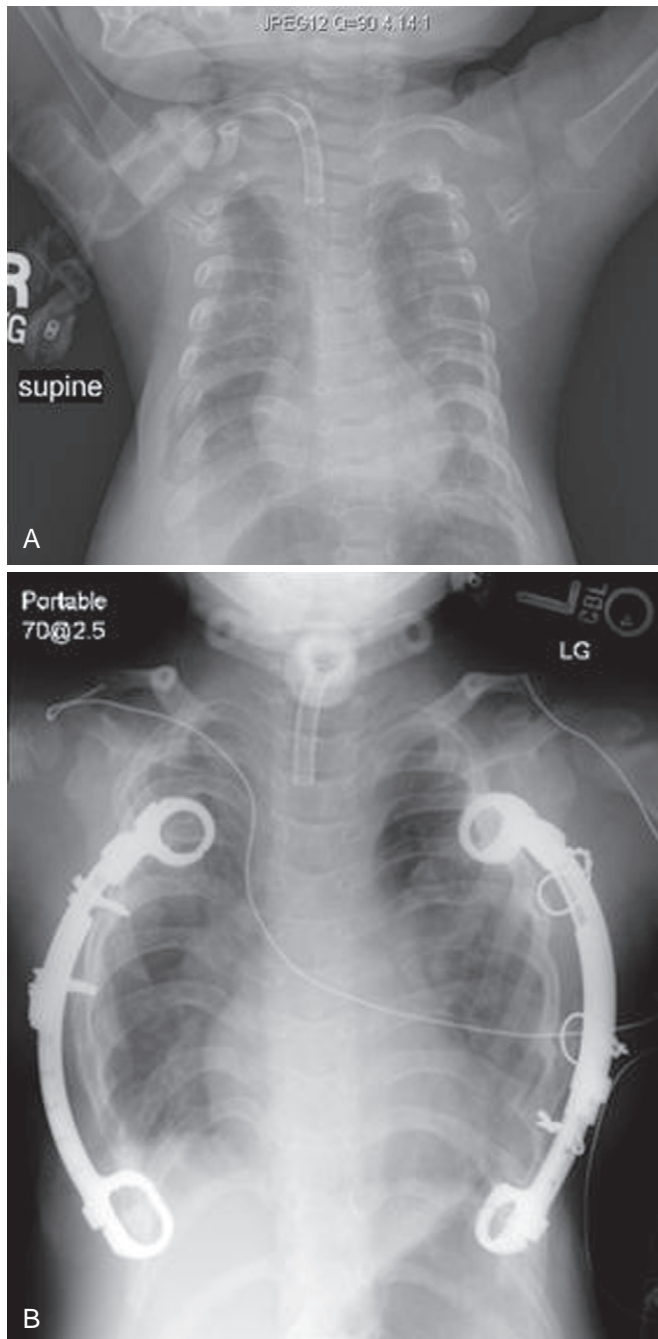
Vertical expandable prosthetic titanium rib device (VEPTR) in a patient with Jeune syndrome. Preoperative (A) and postoperative (B) radiographs of a child who required 24-hour ventilatory support before surgery and only nocturnal ventilation after repair. (Courtesy John H.T. Waldhausen, MD.)
